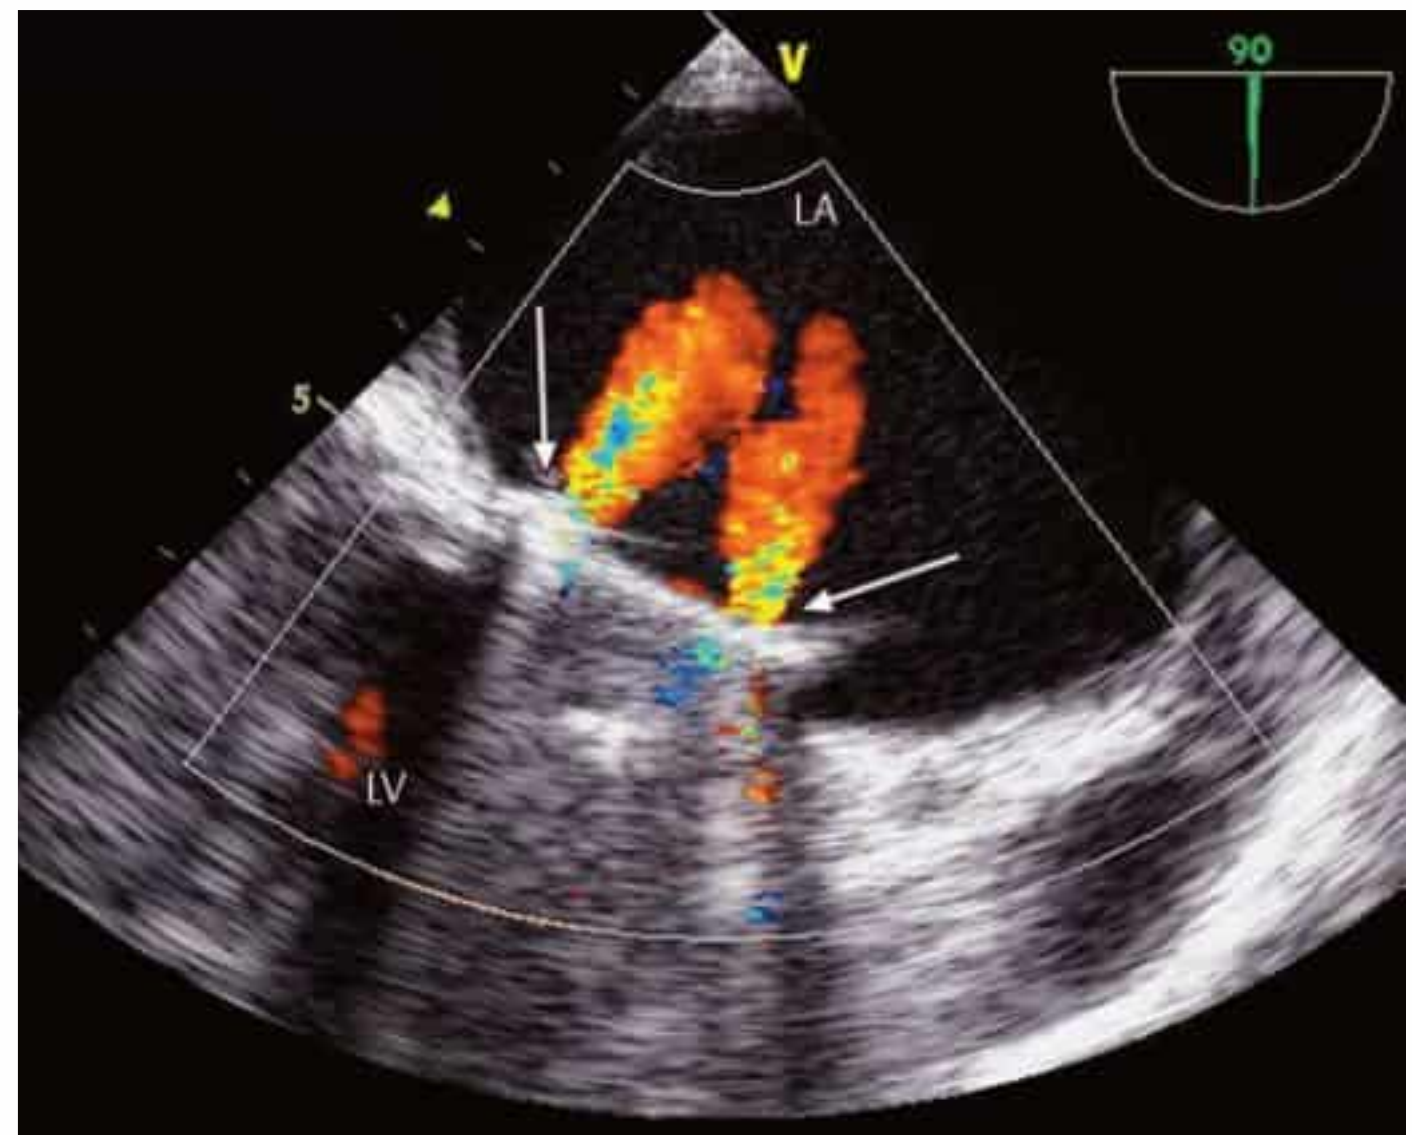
Double-disk valve. Typical color Doppler view shows two regurgitant jets at the disk margins (arrows), a normal finding with this type of valve.
